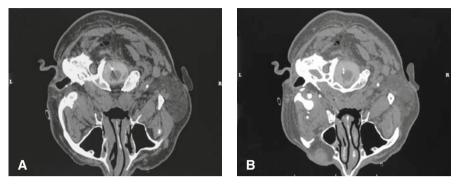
A Final position of the cannula in axial CT slices (left side) in TR-NC. B Final position of the electrode, posterolateral section of the spinal cord, in axial CT slices in TR-NC
